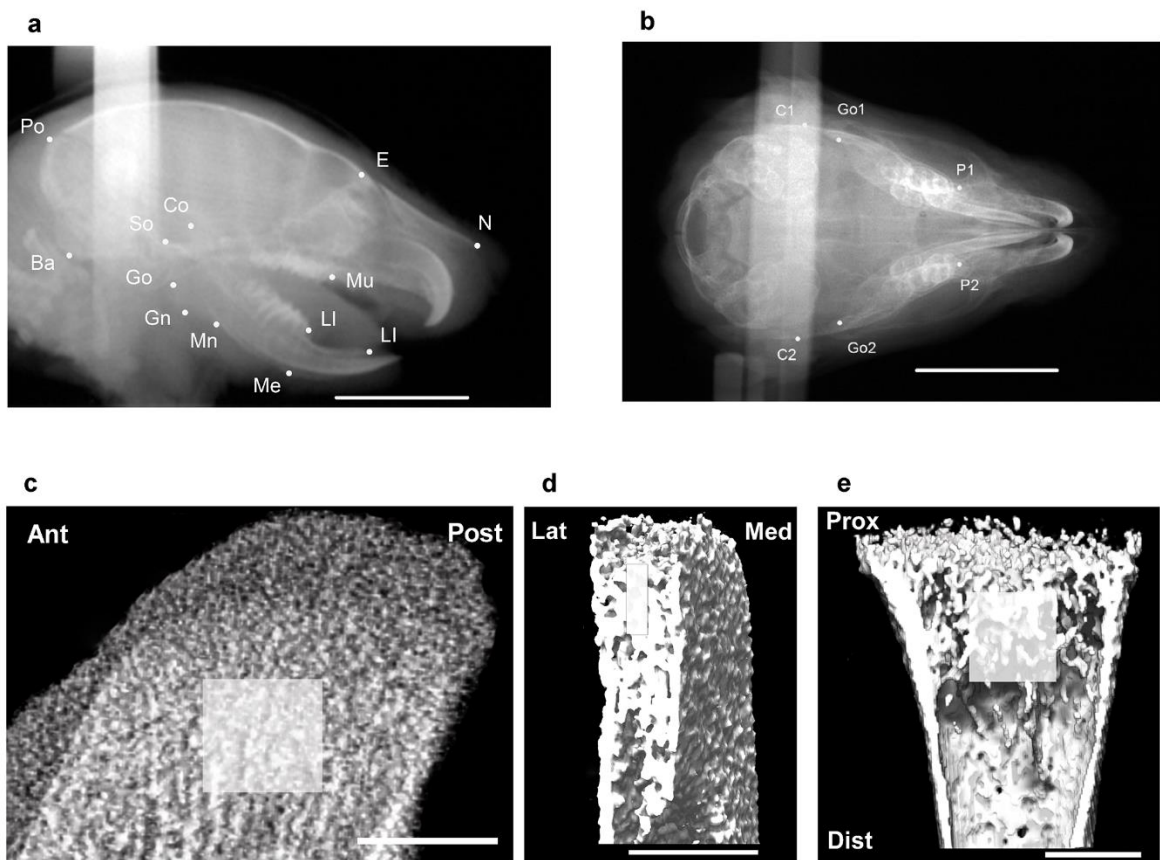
Cephalometric and μ CT analysis landmarks.
